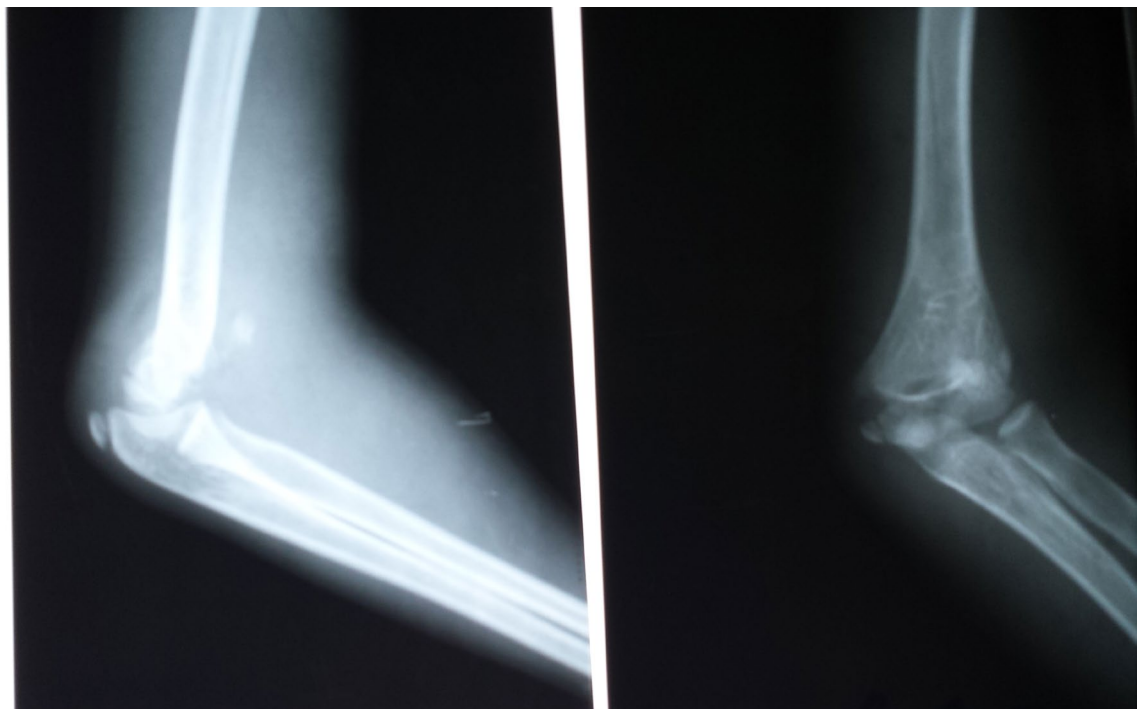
X-ray of the elbow of a patient from current study showing heterotopic ossification on the anterior aspect of the elbow.
